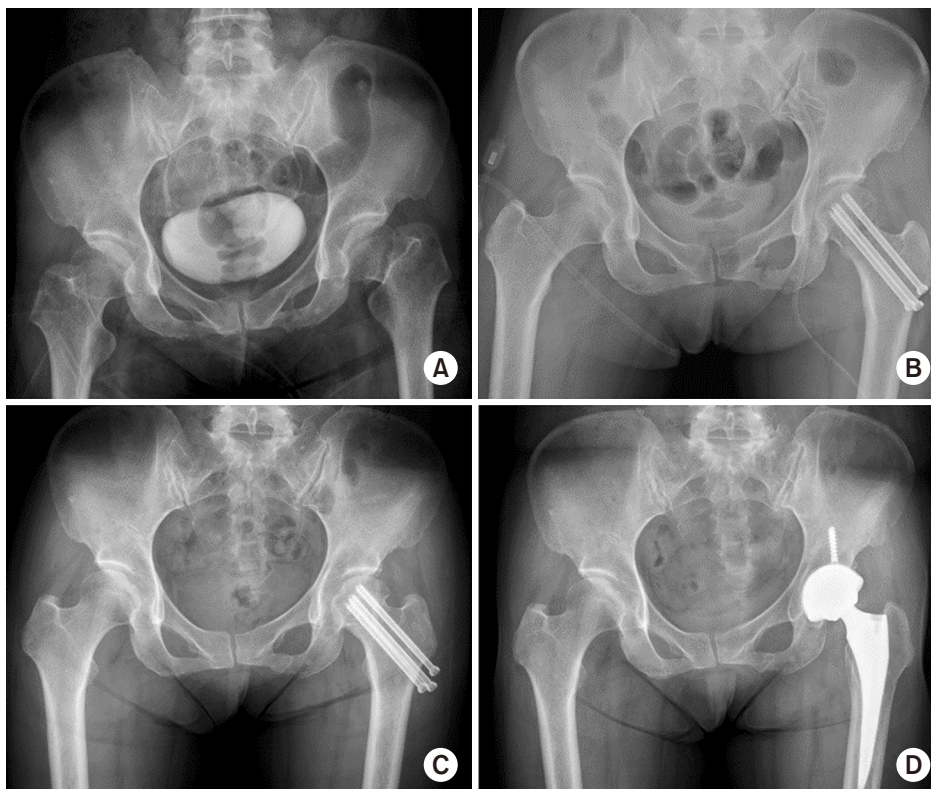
A 65-year-old female demonstrated pain in the left hip and was diagnosed with a femoral neck fracture. (A) Plain radiographs of preoperative pelvis in anteroposterior (AP) view showing displaced fracture of the femoral neck. Due to the general condition of the patient, surgery was performed after 15 hours of the initial trauma. (B) Plain radiographs of postoperative hip in AP view showing osteosynthesis with cannulated screws. (C) Plain radiographs of hip in AP view at follow-up demonstrating varus hip due to the avascular necrosis of the femoral head and neck. (D) Plain radiographs at final follow-up demonstrating a state of total hip arthroplasty due to the internal fixation failure of the femur neck fracture.
